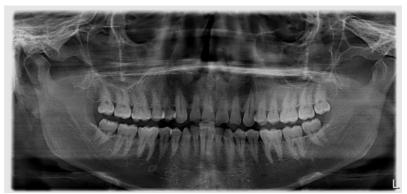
Orthopantomogram of the patient which revealed normal trabecular bone pattern in maxilla and mandible
